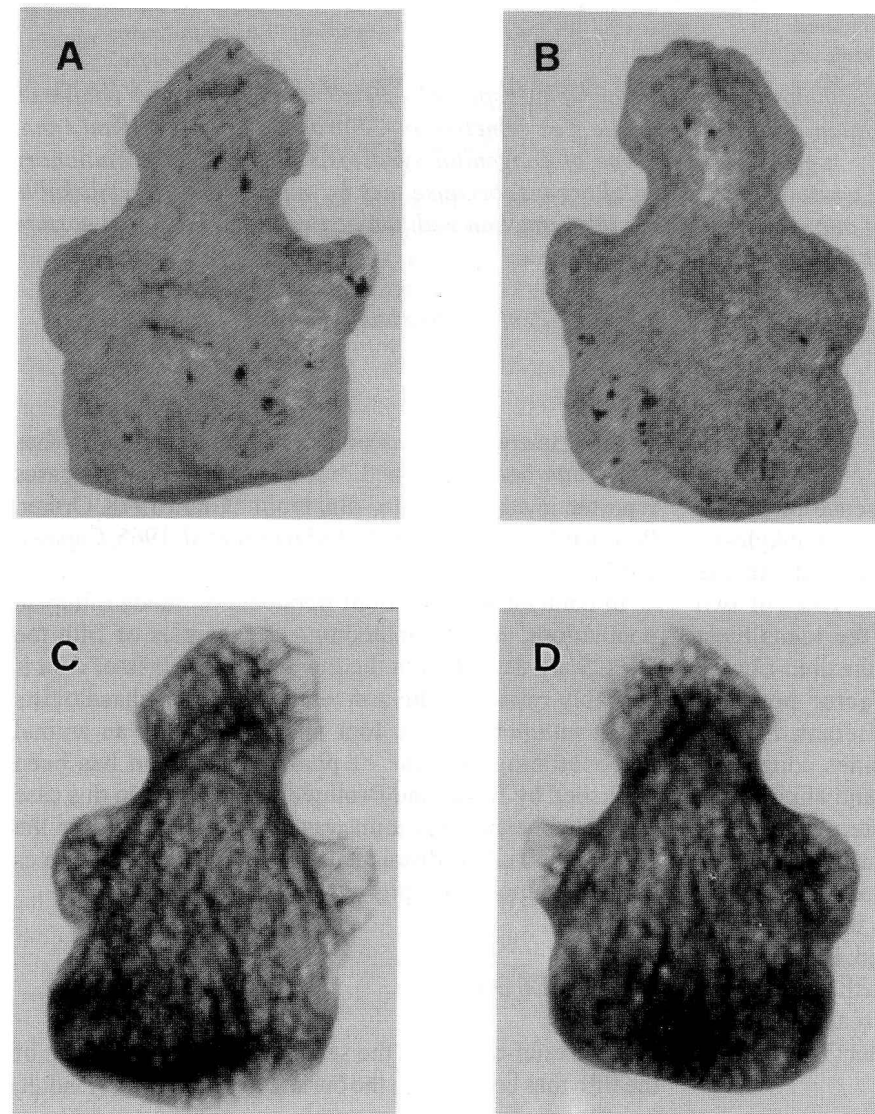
Macroscopic aspect of the ventral (A) and dorsal (B) surface of the fused distal phalanges of the fifth toe with corresponding radiographic aspect (C and D).
